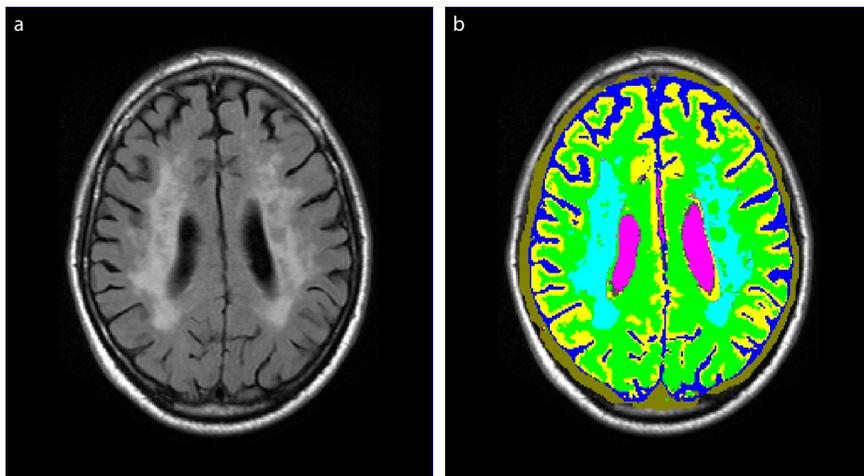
(a) MR FLAIR image of a patient with extensive WML, visible as white areas and (b) the result of segmentation based on the automated KNN-based algorithm.
